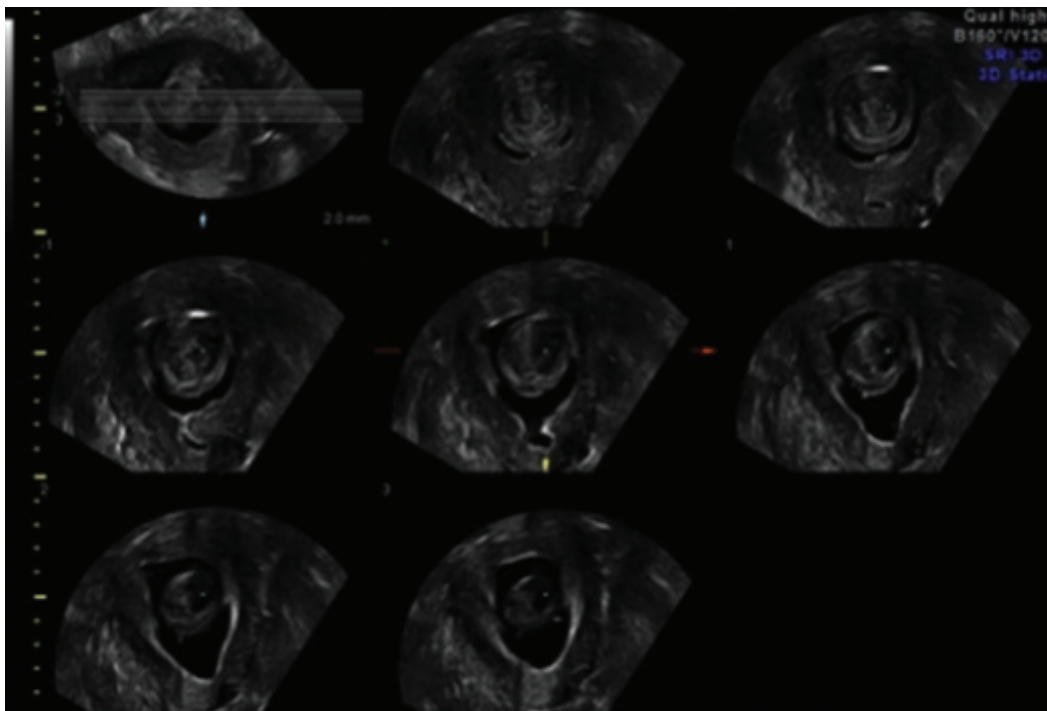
Saline sonogram of submucosal fibroid tomographic ultrasound image (TUI).
